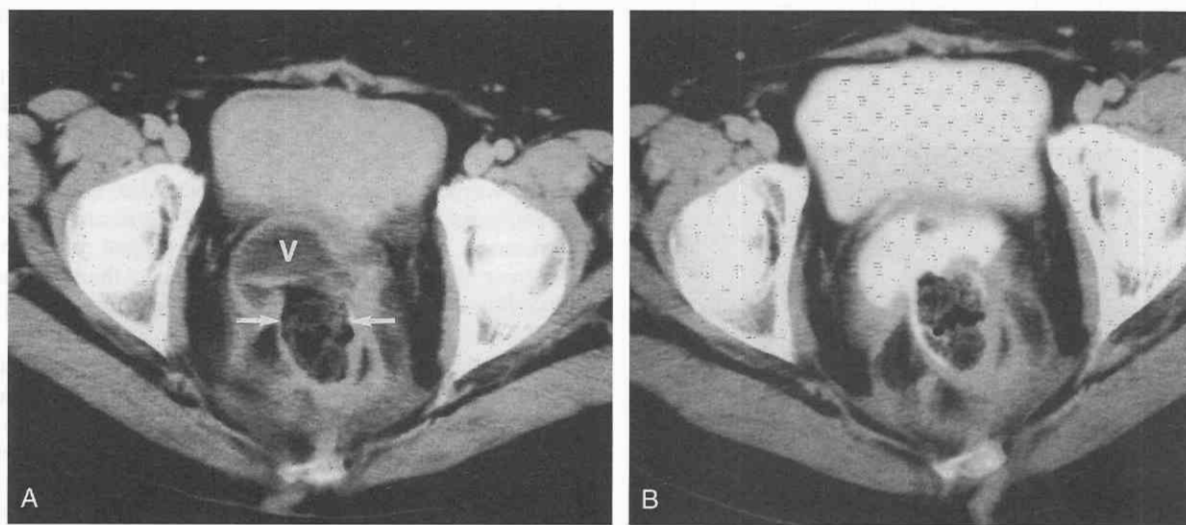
Radiation-induced fistulas. CT scan through the pelvis after radiation therapy for cancer of the cervix. A, Shown are fecal material (arrows) within a fistula between the rectum and the vagina (V) and a sliver of high-density contrast agent (arrow). B, Delayed excretory-phase image with contrast-filled urine in the bladder shows filling of the vagina with contrast of similar density to that in the rectum.
